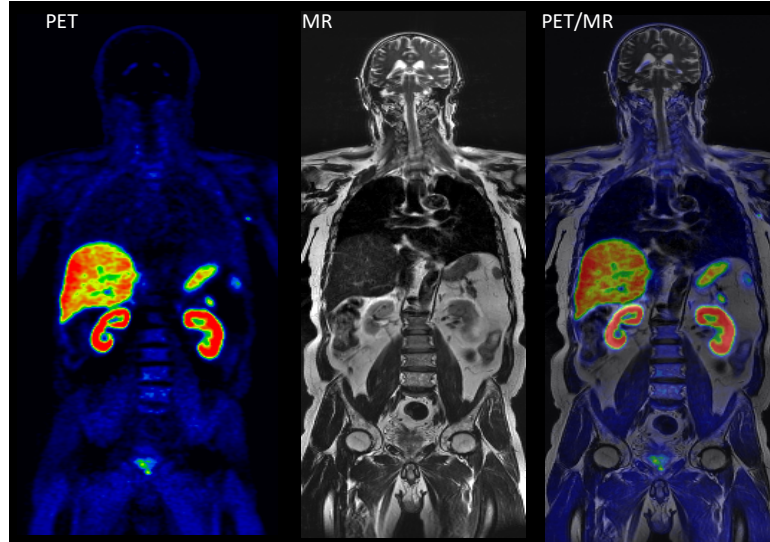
A coronal whole-body PET, MR imaging and PET/MR image comparing the ^{18}F choline prostate imaging (55 min uptake and 6 bed positions). Note that the integrated PET/MR provides superior soft tissue contrast for oncological applications such as prostate cancer (*Courtesy University Hospital Zurich*).
